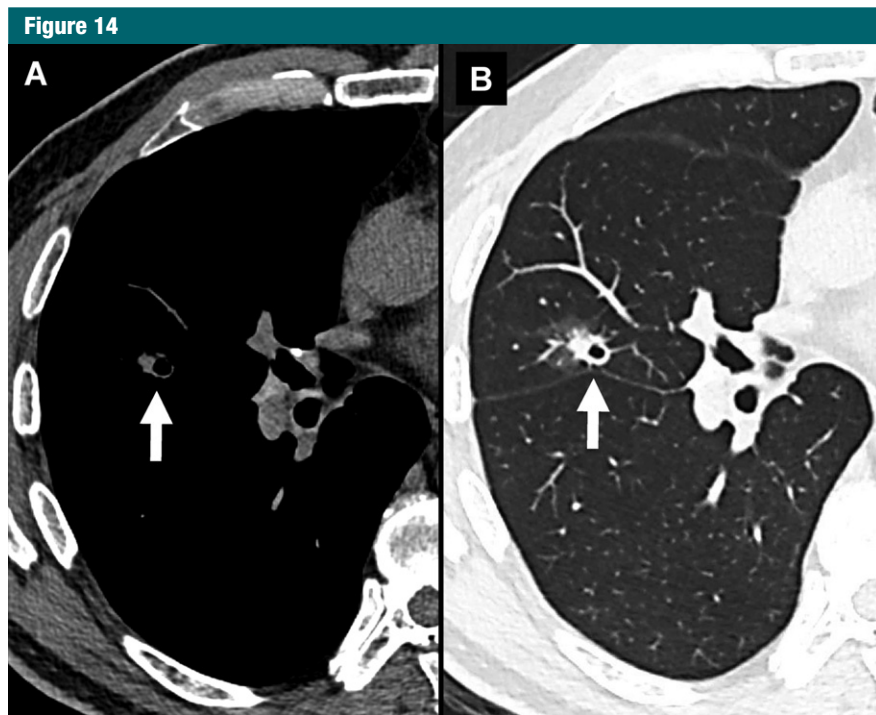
Transverse CT sections through a nodule (arrow) in the right upper lobe. *A*, Image obtained with the mediastinal window setting shows only the core of the solid nodule component. *B*, Image obtained with lung window settings shows the entire solid component and the cystic and ground-glass components of the nodule. Thus, all nodule measurements should be performed on images obtained with lung window settings.
